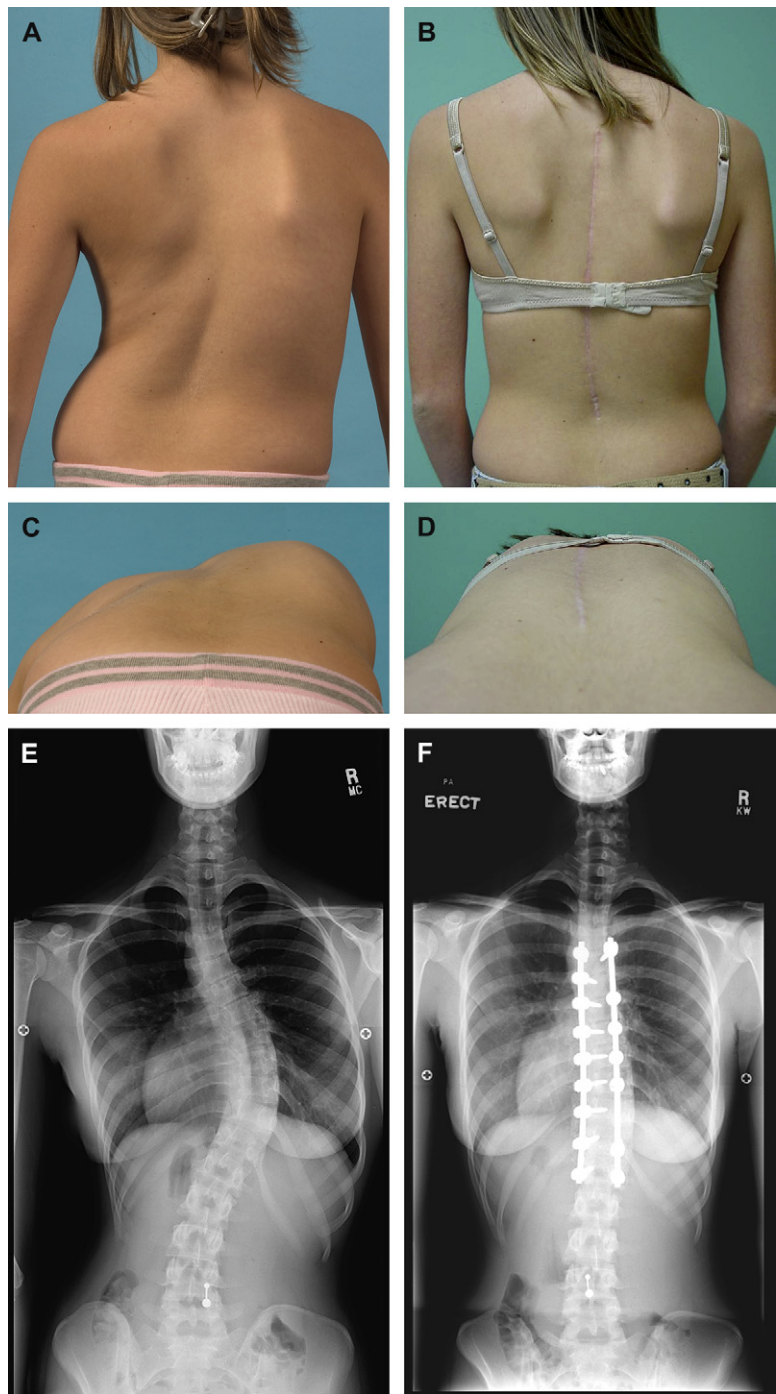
Clinical photographs and radiographs before and after surgery (2-year follow-up) of a 13-year-old girl with AIS. Note correction of truncal shift, thoracic torsion, rib asymmetry, and rib prominence on forward bending after surgery with segmental pedicle screw fixation and vertebral derotation without thoracoplasty. (A) Preoperative clinical photograph. (B) Two-year postoperative clinical photograph. (C) Preoperative forward bend photograph. (D) Two-year postoperative forward bend photograph. (E) Preoperative posteroanterior radiograph. (F) Two-year postoperative posteroanterior radiograph.
